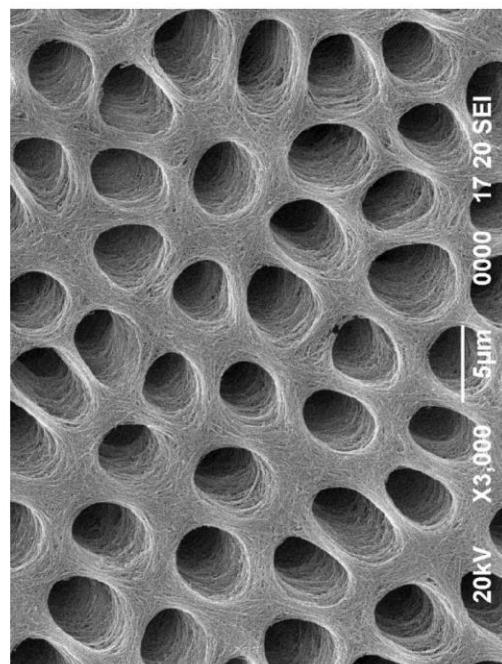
SEM image of the dentin block surface after placing in 40% phosphoric acid for 1 min followed by 5.25 % NaOCl for 10 min with ultrasonication
